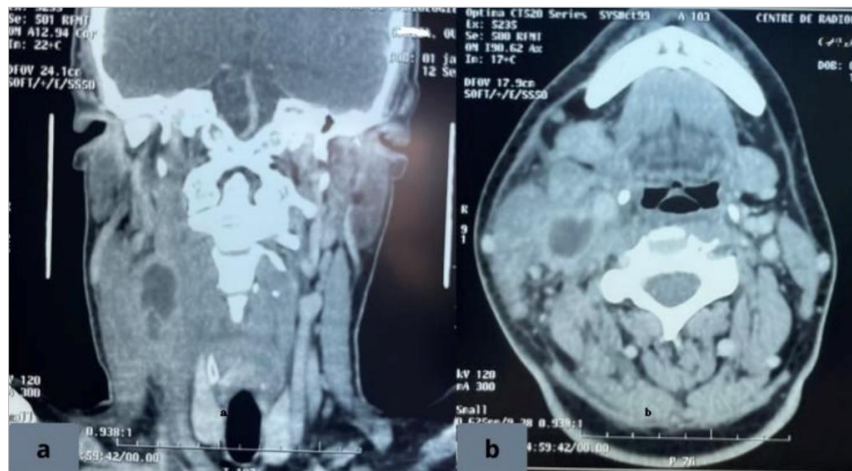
CT scan slices showing Bezold's abscess. a - Coronal view. b - Axial view.
